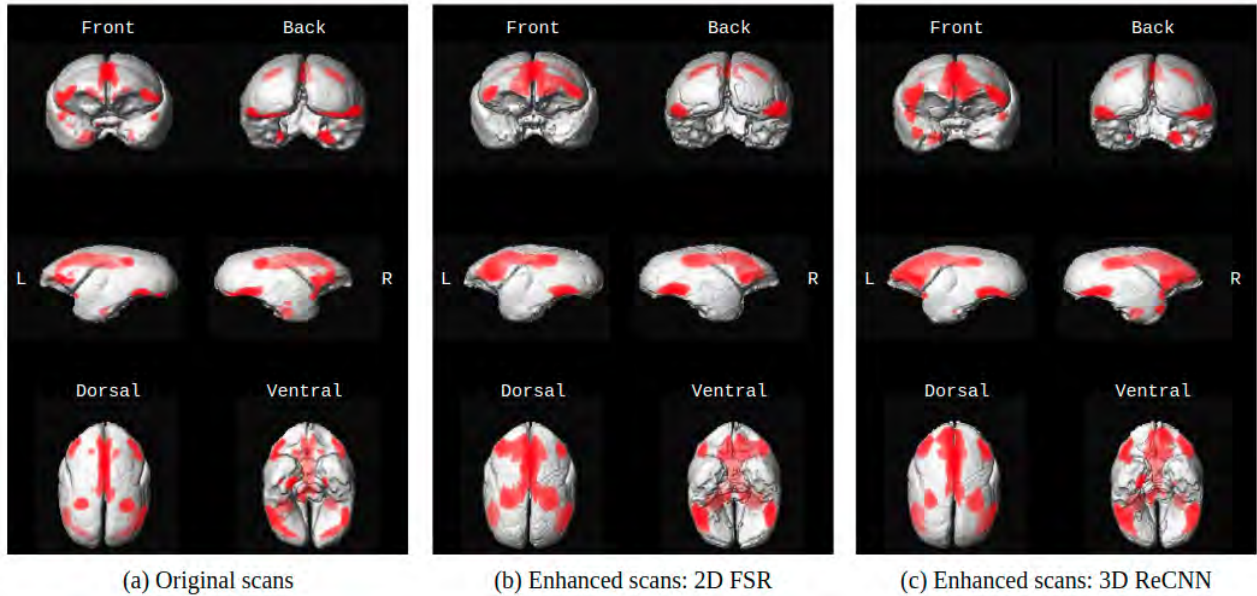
VBM analysis of GM decrease for 185 MRI scans from 42 marmosets with an age range of 2.5 to 14.7 years using smwGM segmentation from (a) original scans, (b) enhanced scans by 2D FSR, and (c) enhanced scans by 3D ReCNN. Darker shades of red represent a more significant decrease in a specific region than lighter shades.
